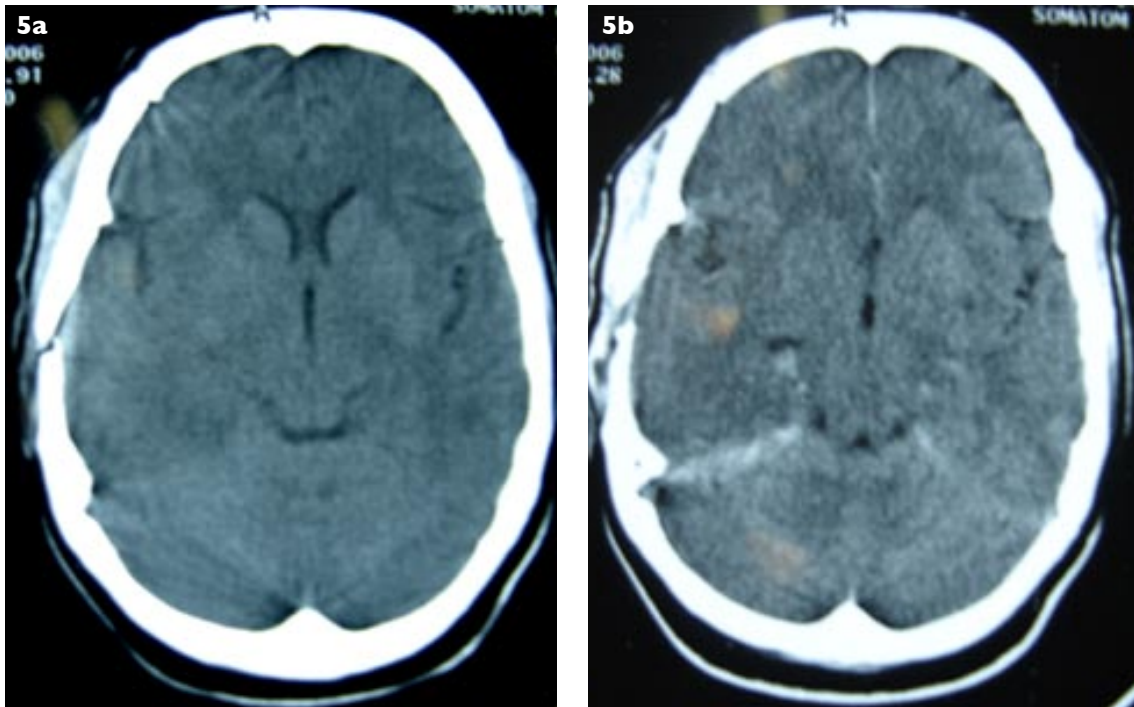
Post-craniotomy (a) pre- and (b) post-enhancement axial CT images show contrast enhancement along the petrous attachment of side of tentorial cerebelli.
